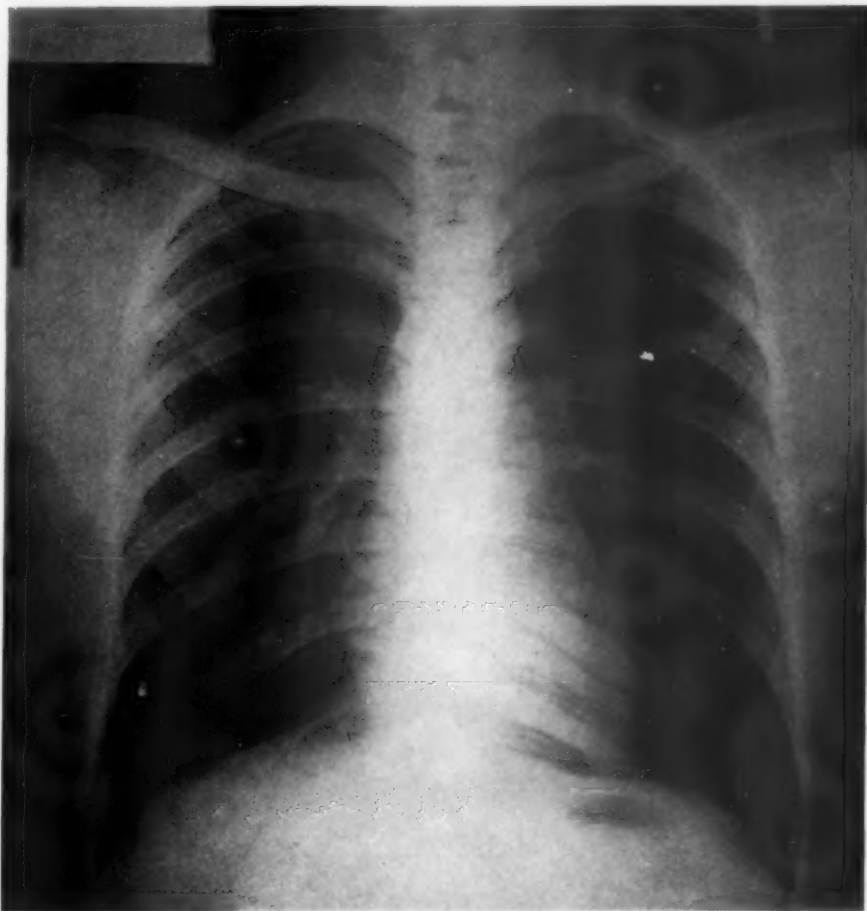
(Case 3.) Roentgenogram taken August 10, 1933. Complete clearing of the infiltration in the right lung.
